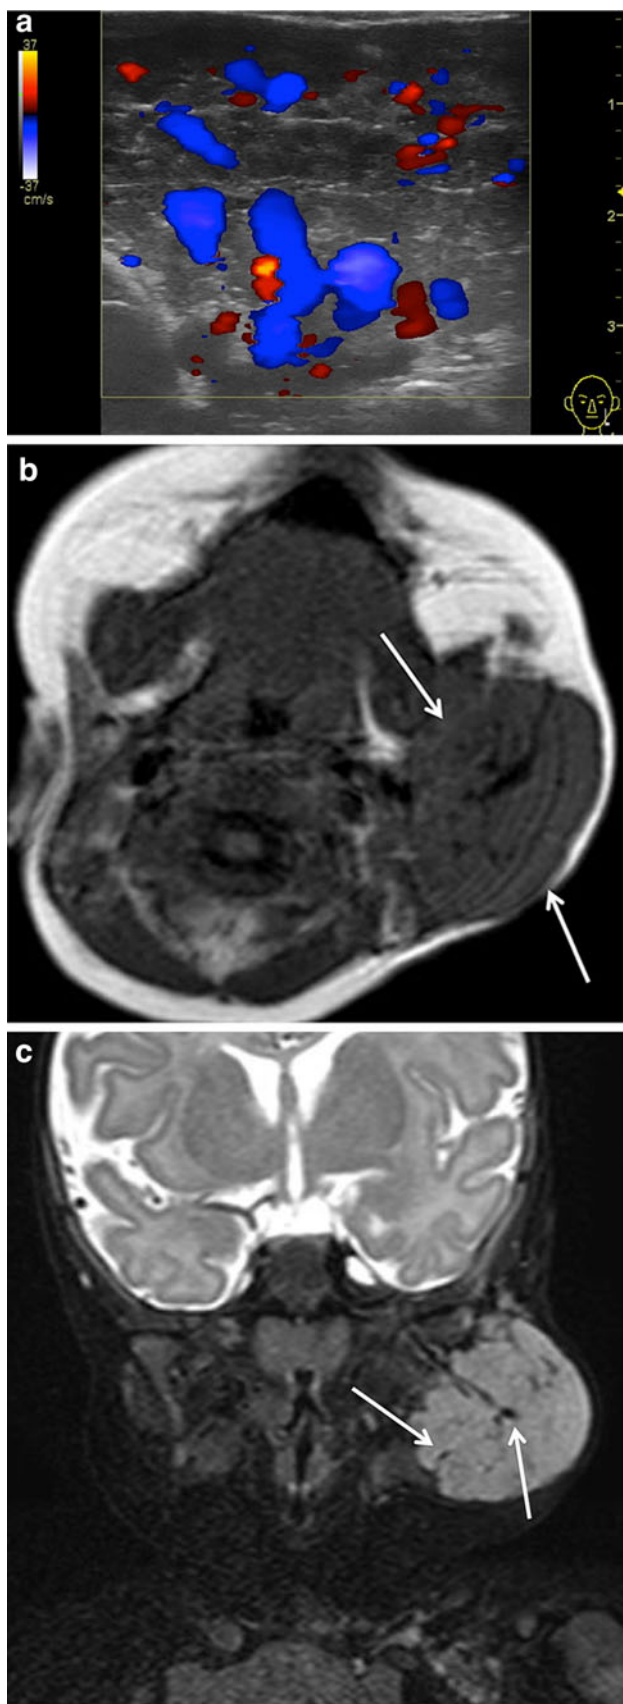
Infantile hemangioma in the proliferative phase on the cheek of a 13-month-old boy. b Axial T1-weighted MR image shows a well-defined mass, isointense to muscle (*arrows*). c Coronal fat-saturated T2-weighted MR image of the neck shows high intensity to muscle with flow voids (*arrows*). a Color Doppler US demonstrates arterial flow within a mass
